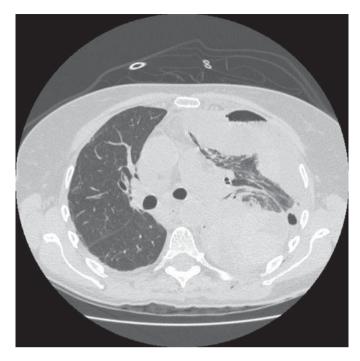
A CT scan of the chest showing organized empyema, with fibrous thickening of the pleura and a 'multichambered' appearance (two separate 'pockets' not in communication with each other).
